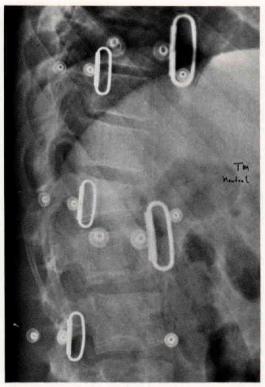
Standing lateral X-Ray view of Case No. 1 in forward flexion in TLSO.
